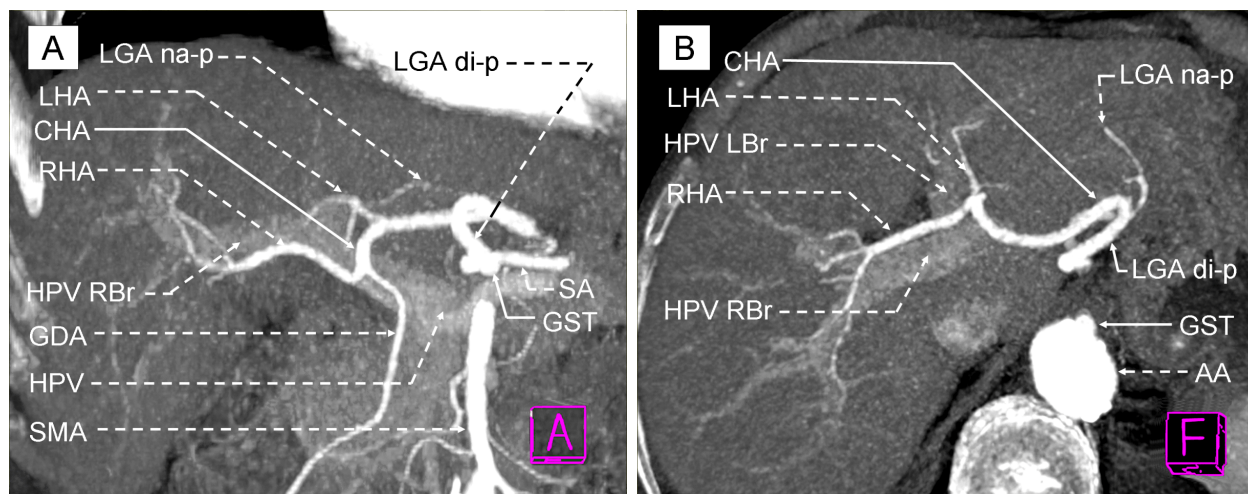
MDCT angiography with 3D reconstruction of the AA, GST, SMA and CHA arising from LGA. VRT image after subtraction of the vertebral column and the kidneys: antero-inferior aspect. MDCT: Multidetector computed tomography; 3D: Three-dimensional; AA: Abdominal aorta; GST: Gastro-splenic trunk; SMA: Superior mesenteric artery; CHA: Common hepatic artery; LGA di-p: Left gastric artery – dilated portion; LGA na-p: Left gastric artery – narrowed portion; VRT: Volume rendering technique; SA: Splenic artery; LHA: Left hepatic artery; RHA: Right hepatic artery; GDA: Gastroduodenal artery; LRA: Left renal artery.
